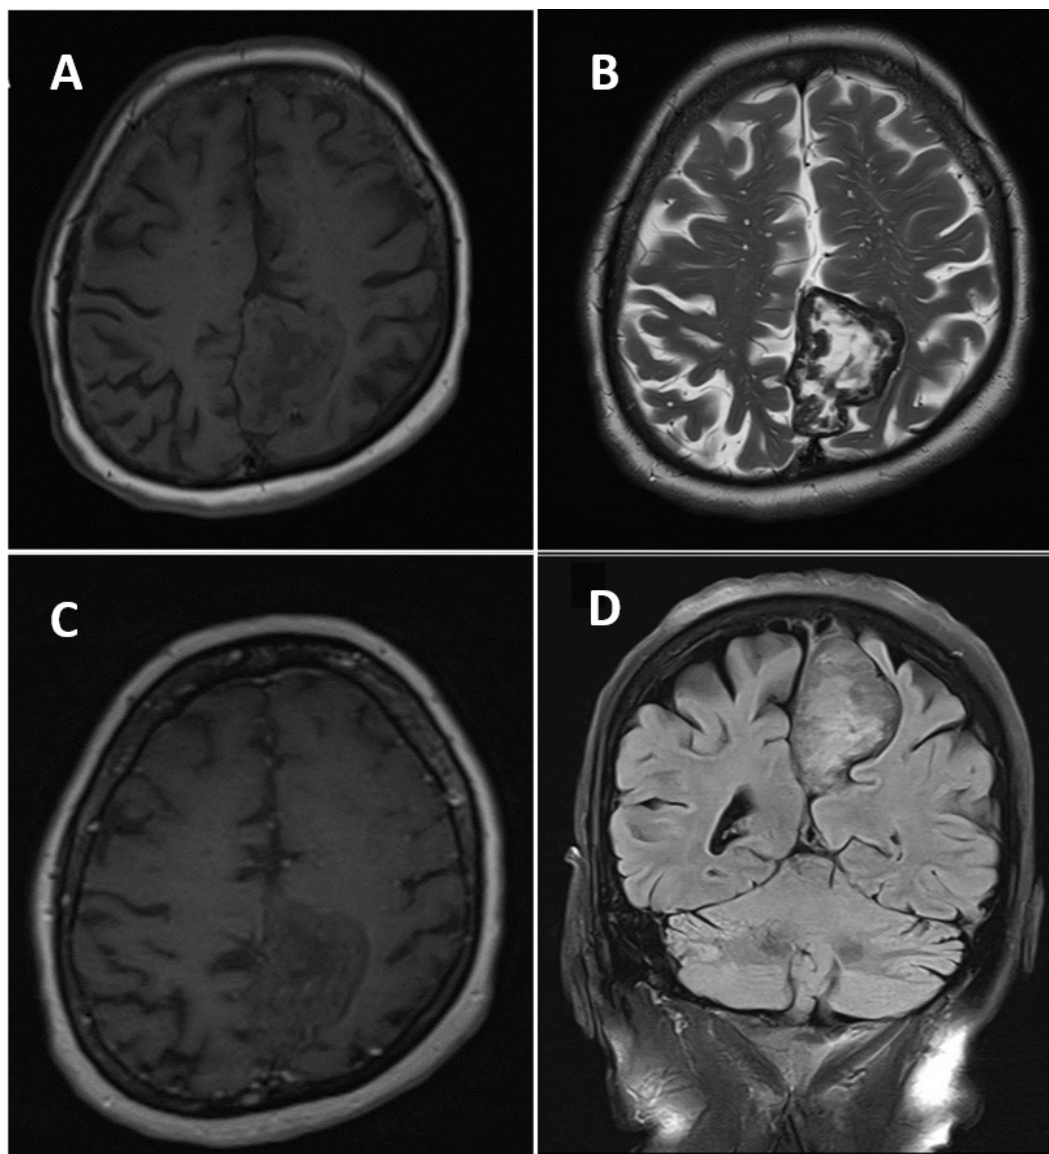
Preoperative MRI images. A. Axial T1-weighted MRI. B. Axial T2-weighted MRI. C. Axial contrast-enhanced T1-weighted MRI. D. Coronal T1-weighted MRI.
